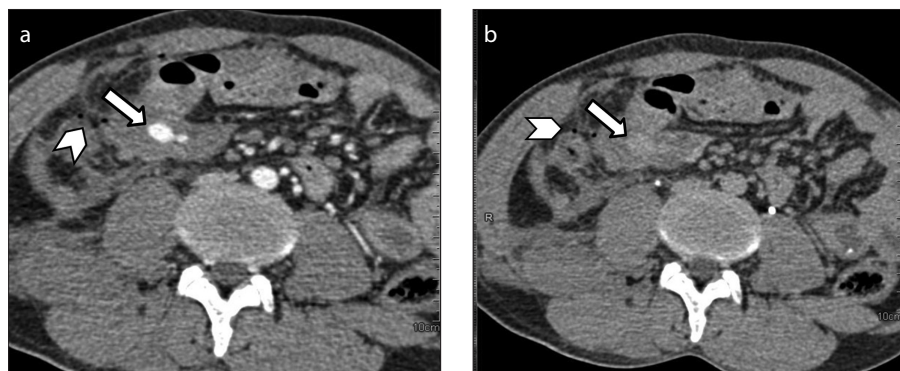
a, b. Axial CT sections at portal venous phase (a) and delayed phase (b) show mesenteric hematoma with a blob of contrast, which increases in size on delayed phase (white block arrow) suggestive of active extravasation. Few foci of extraluminal air were also seen (white arrowhead) and diagnosis of active mesenteric contrast leak with ileal injury was made. Intraoperatively, there was an ileal perforation 6 cm proximal to ileocecal junction with active bleeding in the ileal mesentery.
